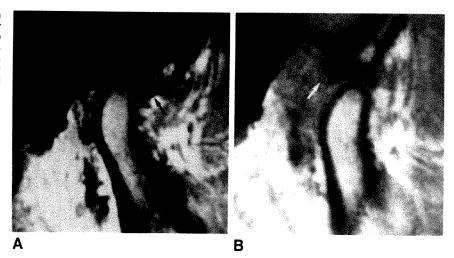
A, T1-weighted sagittal MR image in normal individual with mouth closed. Posterior band is seen as low-signal-intensity structure above apex of condyle; anterior band (arrow) is just anterior to condyle. Thin intermediate zone is not clearly seen but is between two most closely opposed cortical surfaces of temporal bone and condyle. Anterior is to the right.
